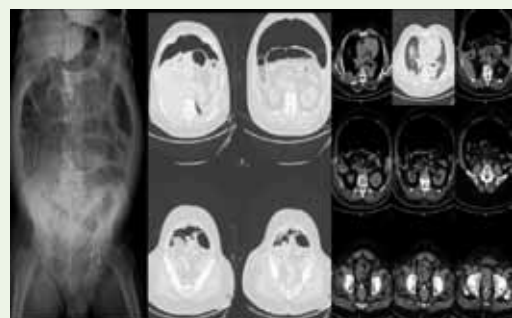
75-year-old male: Large amount of free air in centre of abdomen in the radiograph and confirmed on CT both in soft tissue and bone window in a case of sigmoid perforation.
